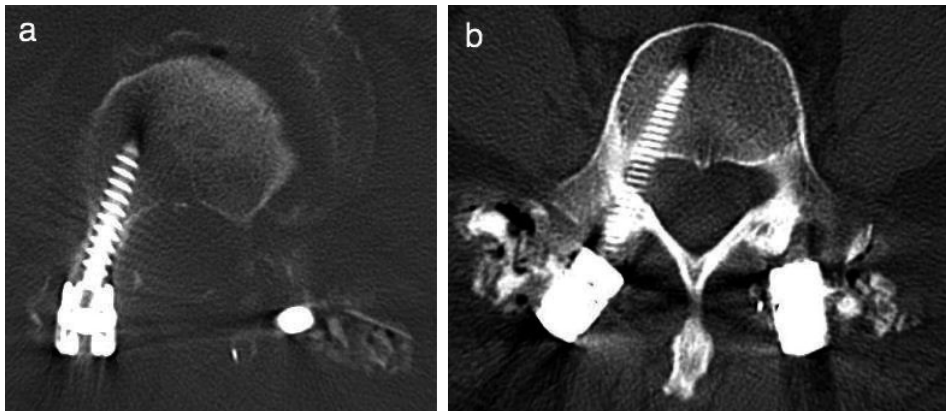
(a) Both surgeons evaluated the right L4 pedicle screw to be within the bony pedicle cortex in a patient with remarkable scoliosis in the coronal plane, in the lumbar CT at two days postoperative. (b) Both surgeons assessed the right L4 pedicle screw to breach the pedicle 4–6 mm medially in the lumbar CT on the first postoperative day.
